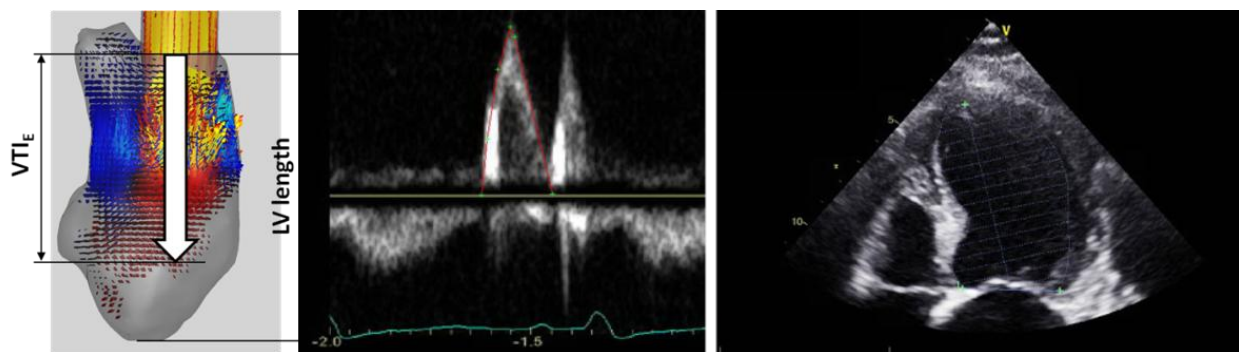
Measurement of E-wave propagation index (EPI). Velocity time integral of the E-wave as measured from pulse Doppler at the mitral valve leaflet tips. The LV length at end diastole as measured from the apical 4-chamber view of transthoracic echo.  $EPI = E\text{-wave } VTI/LV \text{ length}$ .
